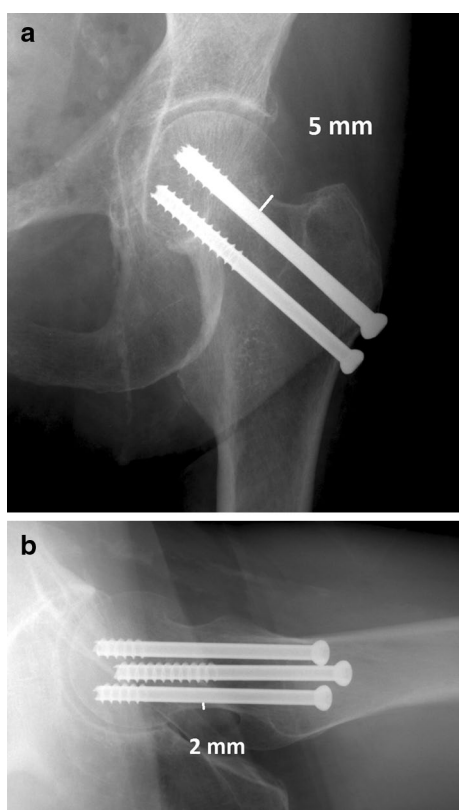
Postoperative anteroposterior (a) and lateral (b) hip radiographs after percutaneous cannulated screw fixation of a valgus impacted femoral neck fracture. The posterosuperior screw appears to be intraosseous on these two views; however the combined distance between the screw and cortex on both views is 7 mm
